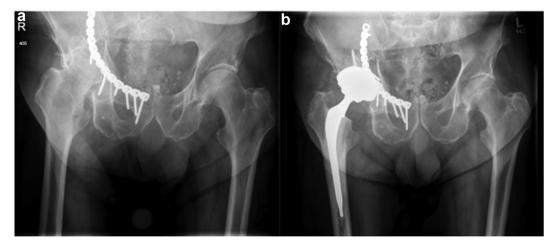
(a) AP radiograph demonstrating post-traumatic arthritis of the right hip following previous open reduction internal fixation for an acetabular fracture. (b) AP radiograph following conversion THA with the ABMS approach. AP, anteroposterior.
